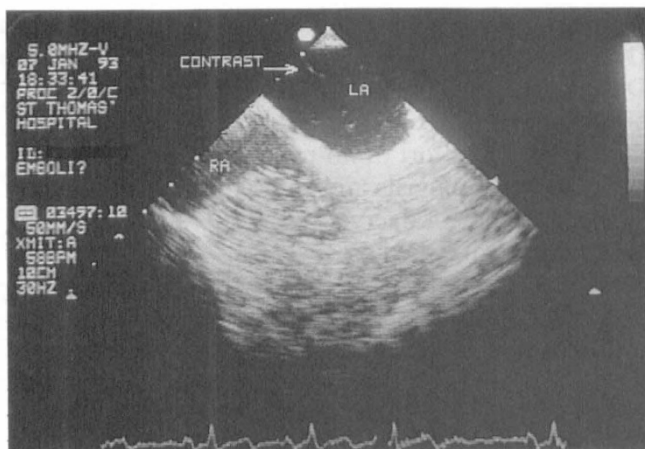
Transoesophageal echocardiography (TOE) demonstrating a patent foramen ovale (PFO) with paradoxical shunting during a Valsalva manoeuvre.
